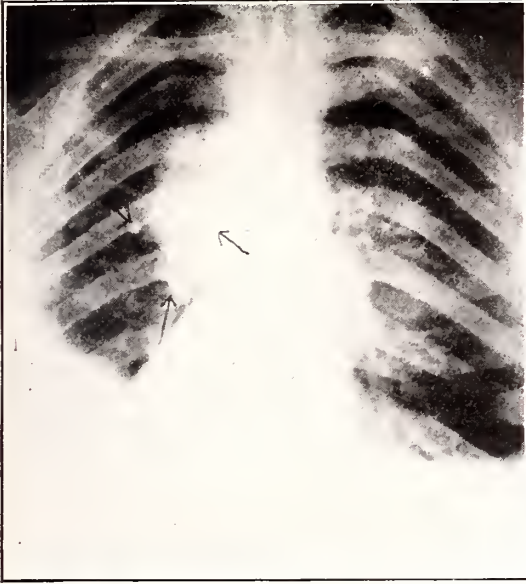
Radiograph taken at the onset of symptoms in a case of carcinoma of the lungs.
